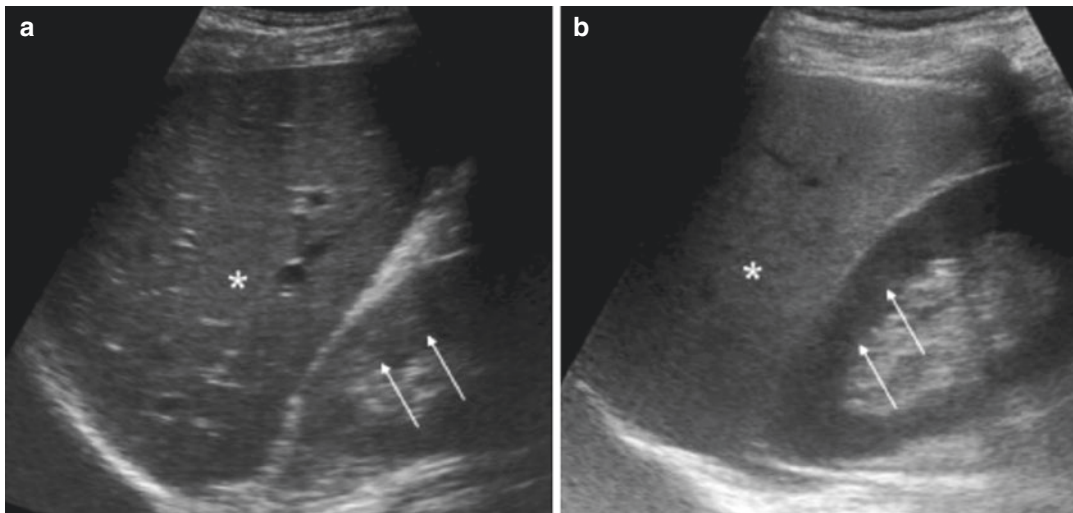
Ultrasound images of a non-steatotic (a) and a steatotic liver (b). In these images, the liver parenchyma is identified by a *star* and the renal cortex is identified by *two arrows*. Echogenicity in healthy (non-steatotic) liver
